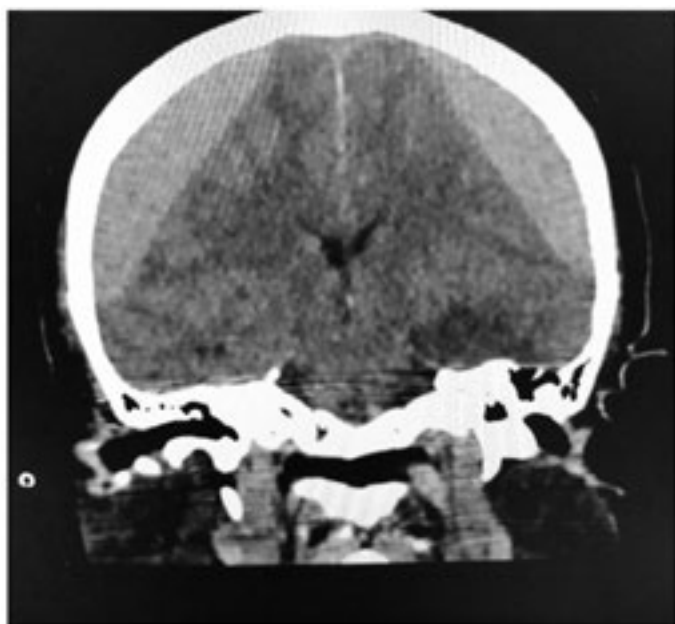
CT brain scan showing bilateral chronic subdural hematoma with hyperdensity.
